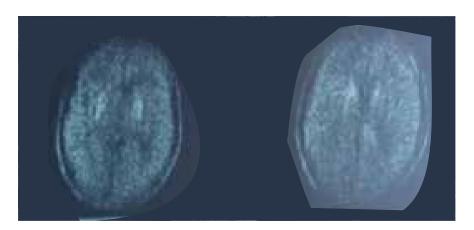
DWI/ADC view showing bilateral symmetrical and non-enhancing areas affecting lentiform nuclei and head of caudate nuclei
